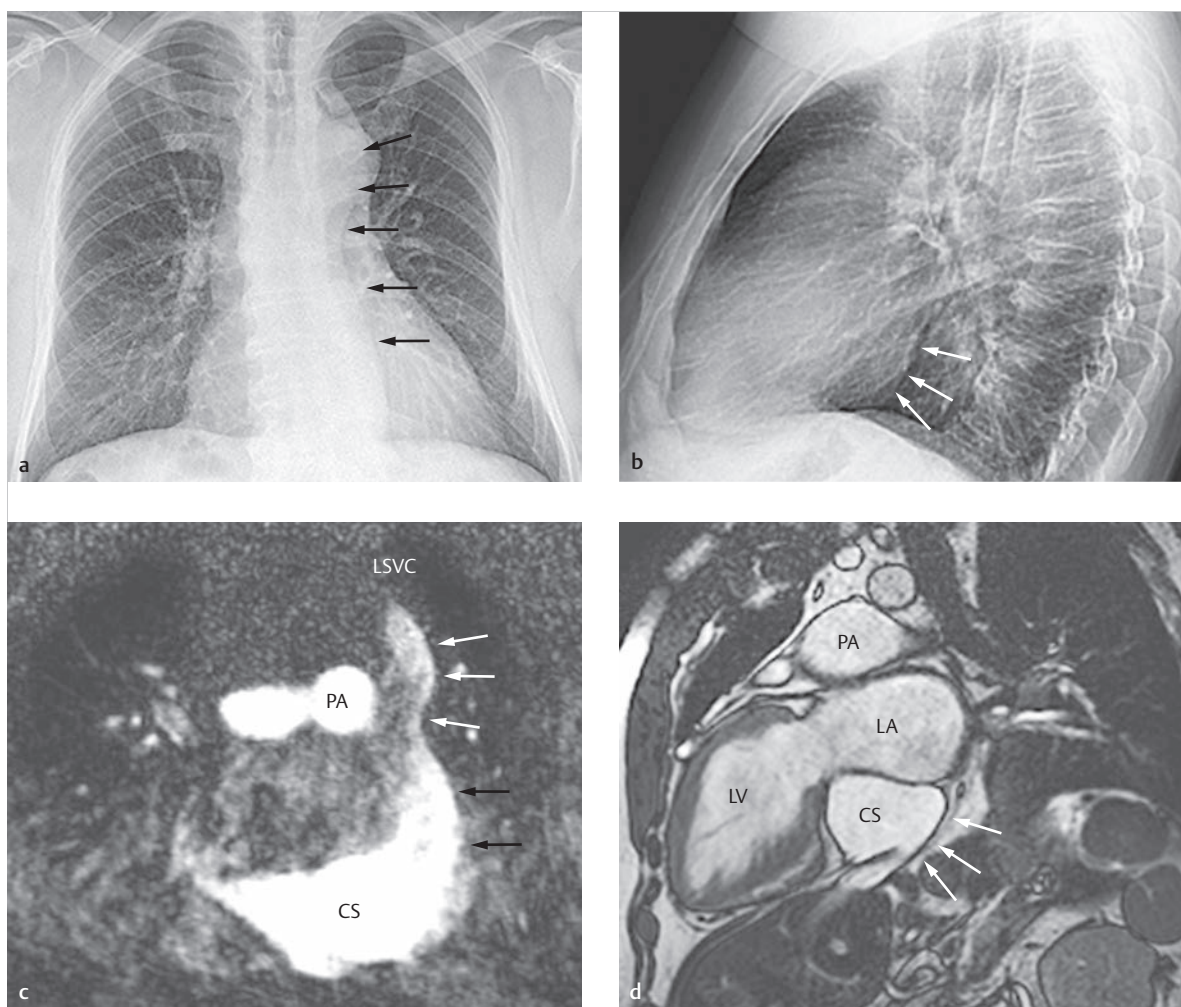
Heterotaxia syndrome, left isomerism, polysplenia, and azygos continuity in a case of absent superior and inferior vena cavas. Fifty-two-year-old male patient. Persistent left superior vena cava with typical connection to the massively expanded coronary sinus and right atrium. Significantly enlarged hemiazygos vein connecting to the persistent left superior vena cava (j); subsequent total anomalous hepatic venous connection directly to the right atrium (i) (asterisk). The corresponding 2-D echo images, 4-chamber view (h, l), also depict the significantly dilated coronary sinus. Due to the nearly perpendicular view, no flow signal can be demonstrated in the coronary sinus using color Doppler (l). Various transverse (e–g, j), sagittal, and coronal SSFP cine MRI views depict the course of the hemiazygos vein as collateral circulation for the absent inferior vena cava, with its connection to the persistent left superior vena cava and enlarged coronary sinus. (Courtesy: Leipzig Heart Center, Dept. of Diagnostic and Interventional Radiology, Leipzig, Germany)
